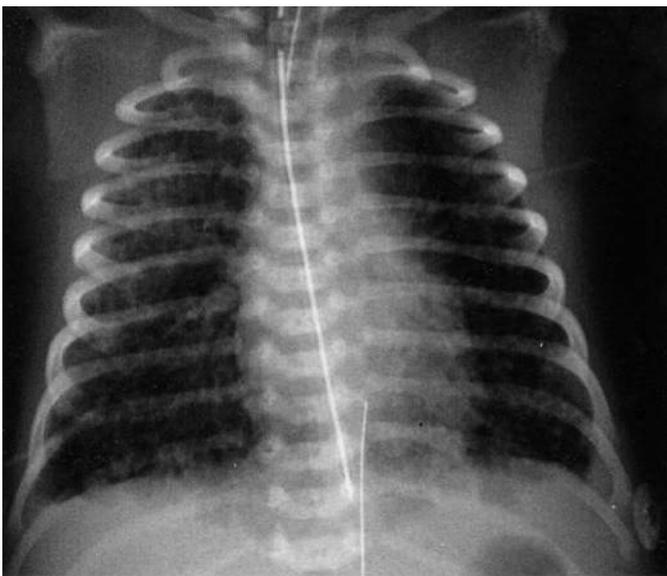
Radiograph of a patient with meconium aspiration syndrome. Anteroposterior radiograph shows diffuse patchy areas of atelectasis and emphysema.
